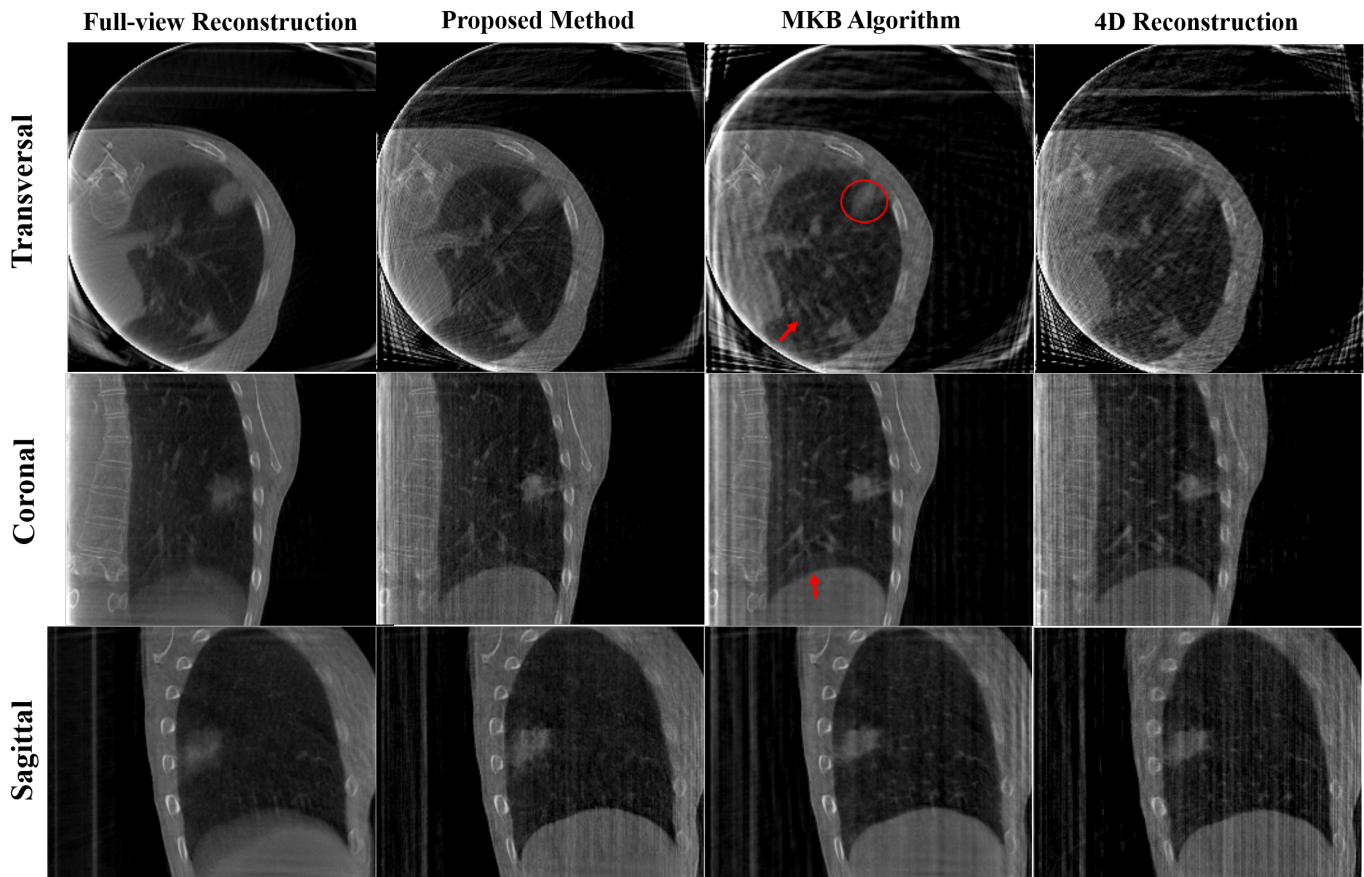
4D-CBCT images of NKI real patient data at first phase bin. A transversal (top row), a coronal (middle row), and a sagittal view (bottom row) are displayed. The prior volumetric reconstruction without phase binning (first column left), the reconstruction of the proposed method (the second column left), the MKB algorithm based reconstruction (third column, middle) as well as the phase-resolved reconstruction by ART (fourth column left) are presented. The red circle indicates the ROI of the tumor-like structure used to evaluate the CNR while the red arrows present the improvements of our method. The gray scale window is $[0.005, 0.035]$.
